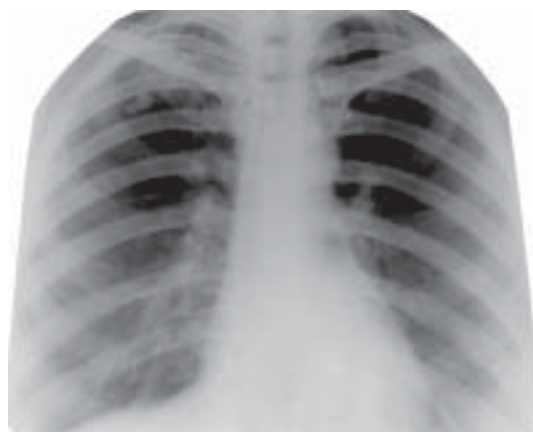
Nidal tuberculosis of the right lung upper part. Observation roentgenogram.
